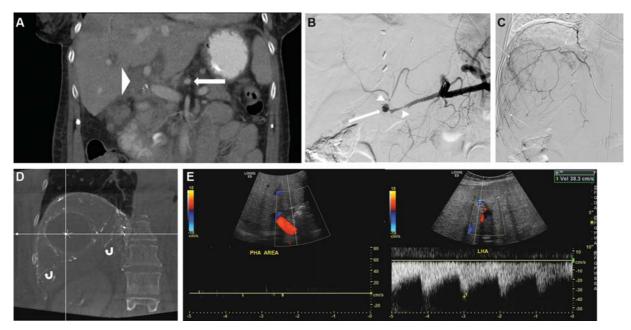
(A) Coronal projection from a CTA (computed tomography angiography) in a patient 2 weeks posttransplantation with acute onset upper gastrointestinal hemorrhage and hemobilia. There is abrupt termination of the common hepatic artery near its origin from the celiac artery (*white arrow*). Additionally, there is ill-defined fluid density material near the porta hepatis (*arrowhead*). (B) Anteroposterior (AP) digital subtraction angiogram after catheterization of the celiac artery demonstrating irregularity of the common and proper hepatic arteries (*arrowheads*) with a 1.2-cm pseudoaneurysm (*white arrow*) from the proper hepatic artery. (C) AP digital subtraction angiogram of the left inferior phrenic artery demonstrates numerous collaterals (*arrows*) to the hepatic parenchyma. (D) Cone-beam CT confirms collateral development to the hepatic parenchyma from the left inferior phrenic artery (*curved arrows*); a large cyst from the donor liver is noted (*asterisk*). (E) After consultation with the transplant surgeon, the patient received surgical repair and reconstruction of the hepatic artery. Three months later, an ultrasound demonstrated thrombosis of the proper hepatic artery repair with enough flow through left hepatic artery, likely from the robust collateralization. The patient had no adverse sequalae.
